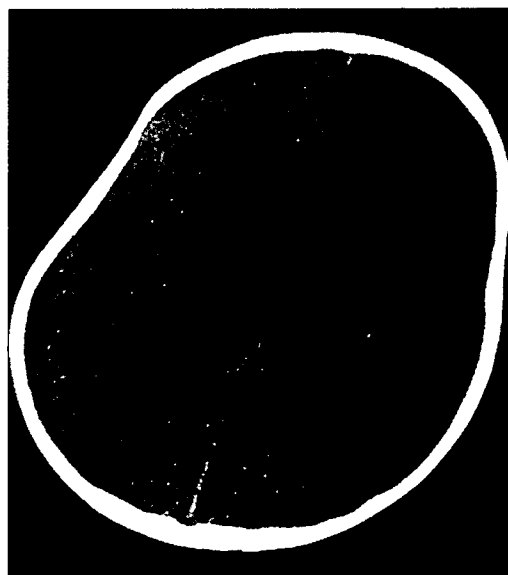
図 IIIc 型 Gaucher 病の CT 像
